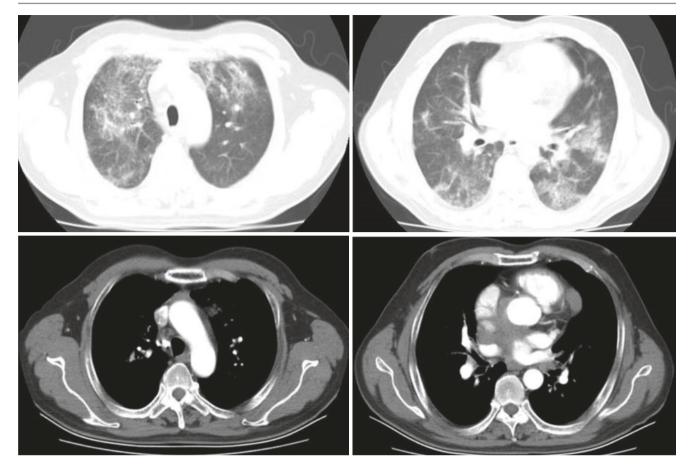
Chest CT images of a 54-year-old man had a history of thymoma for more than 8 years
